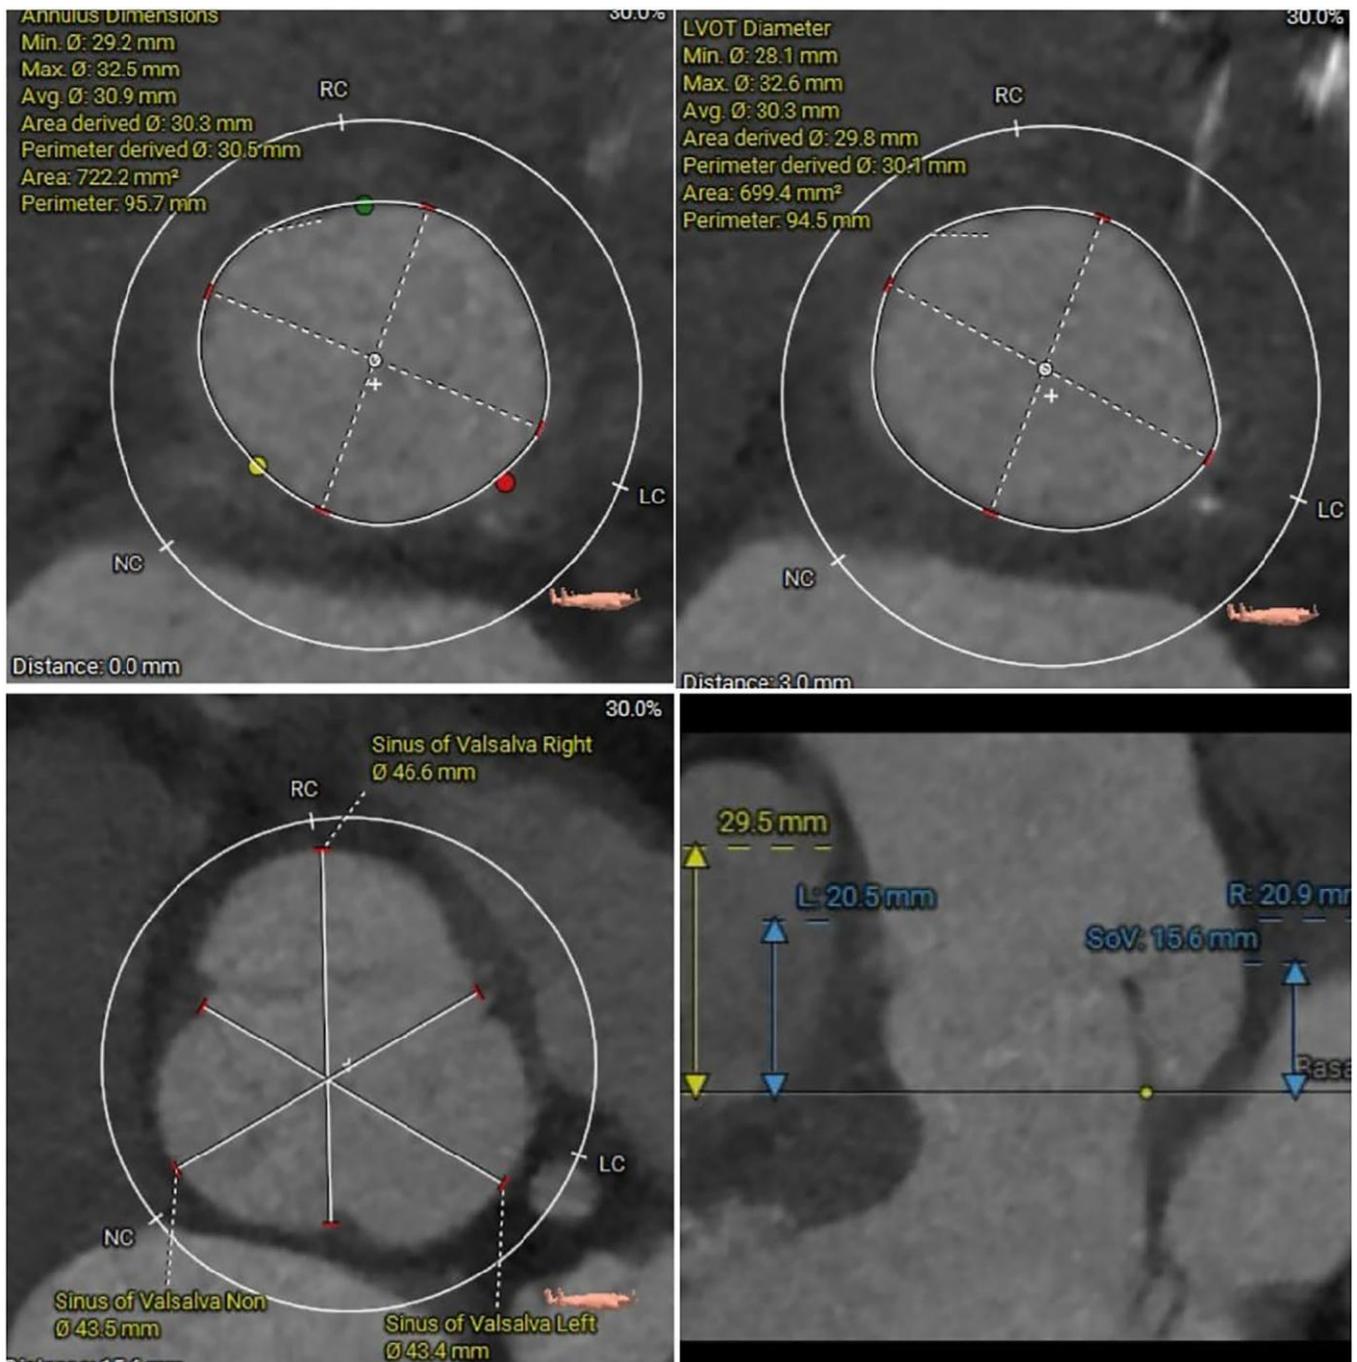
Cardiac computed tomography (CT) scan showing measurements at the levels of the aortic annulus, sinotubular junction, and sinus of Valsalva. [Color figure can be viewed at wileyonlinelibrary.com]
